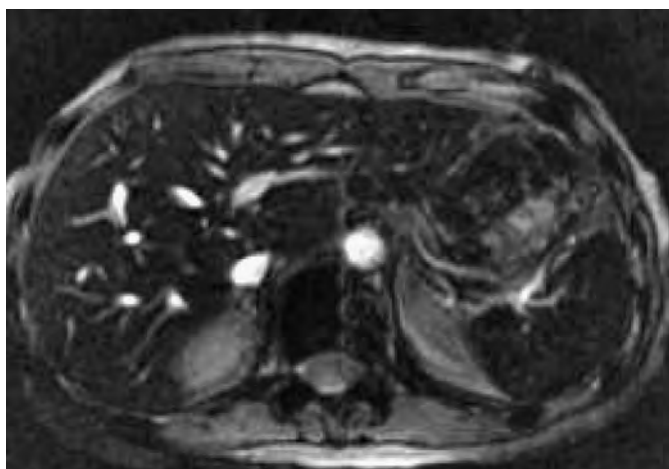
Hemosiderosis in a patient with transfusion-dependent thalassemia. There is marked decreased signal intensity of the liver and spleen compared with the skeletal muscles on axial, gradient recalled echo, T2-weighted MRI.
